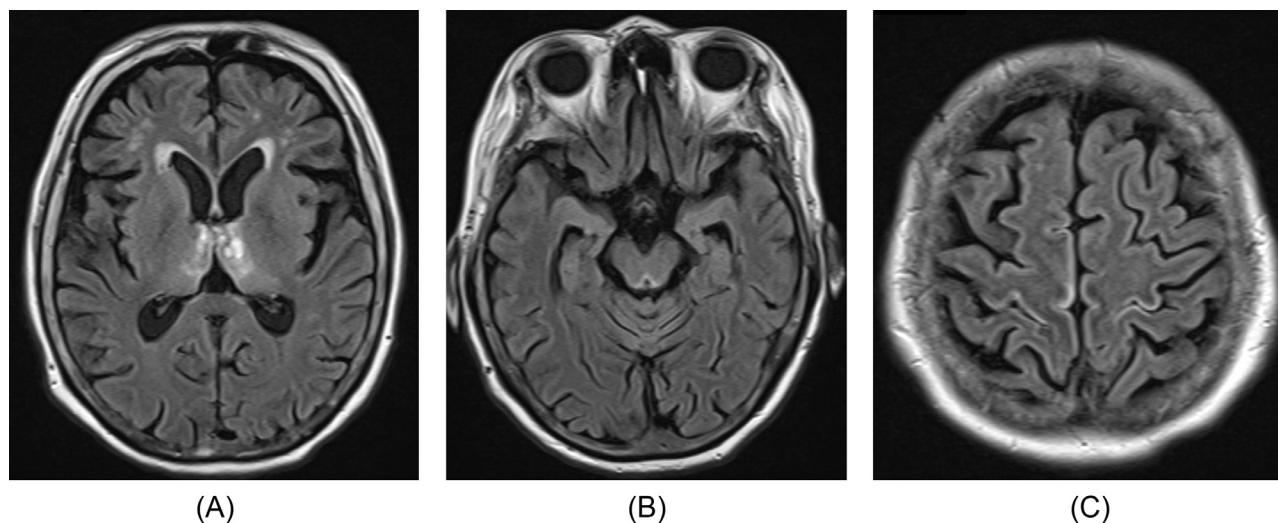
MRI of 2 weeks after starting treatment. The MRI abnormalities in the thalamus (A), cerebral aqueduct (B), and cerebral cortex (C) improved. However, altered consciousness persisted.
